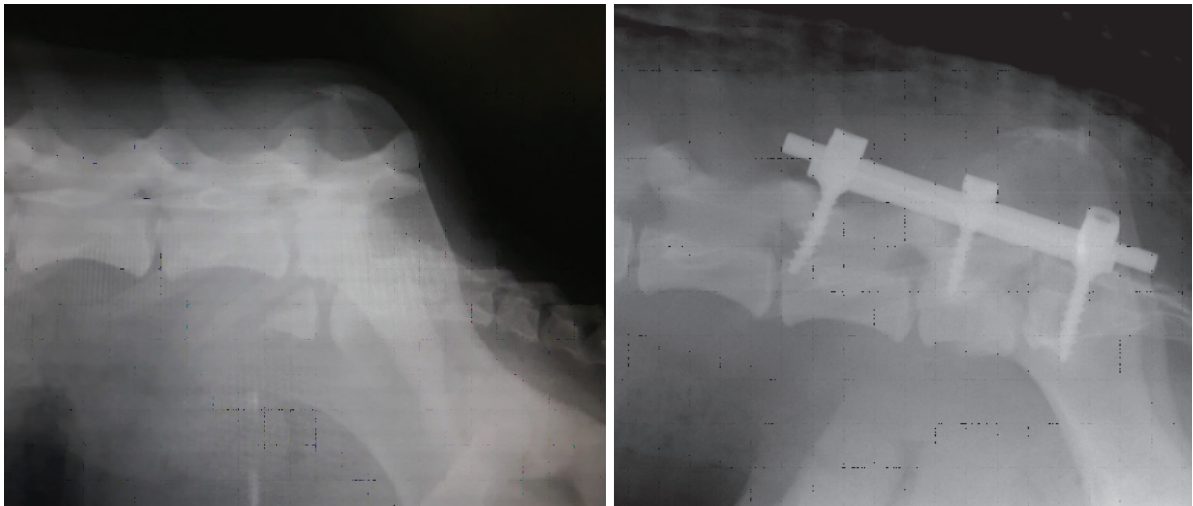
Radiographic images showing spinal column before and after instrument installation
